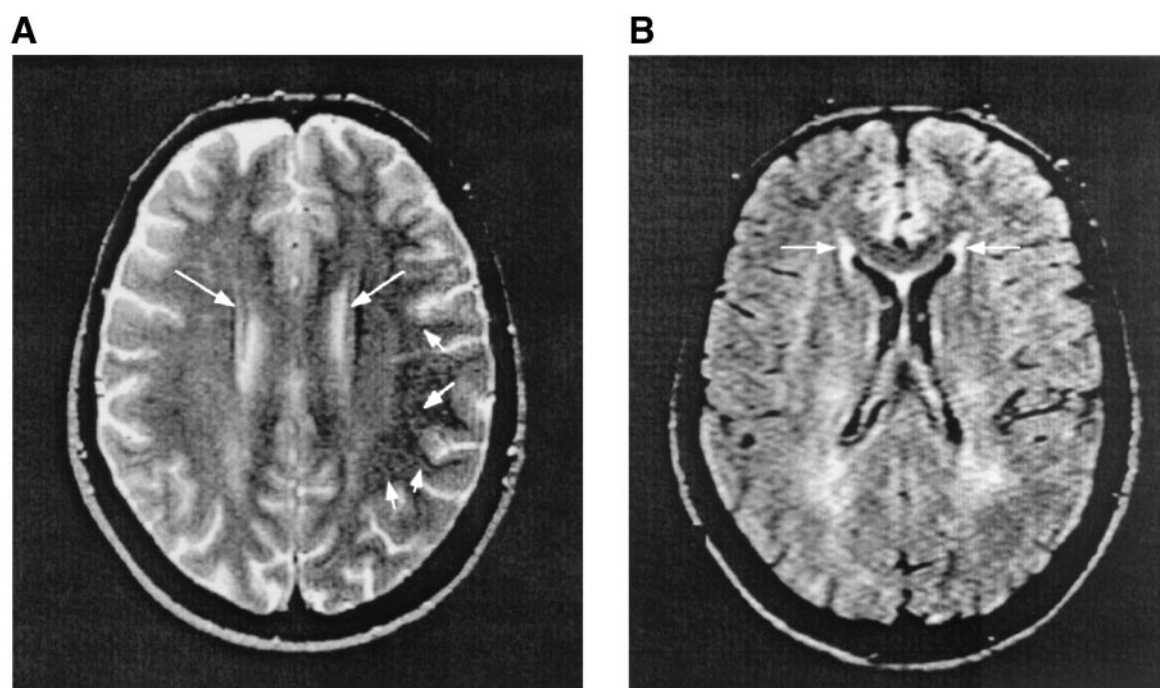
A: A T2-weighted image from a diabetic patient. Note the minimal rim of increased signal around the lateral ventricles (arrow) and the very few enlarged perivascular spaces in the deep white matter (arrowheads). B: Fluid attenuated inversion recovery (FLAIR) image from the same patient showing the rim of periventricular high signal (arrows) more clearly.
